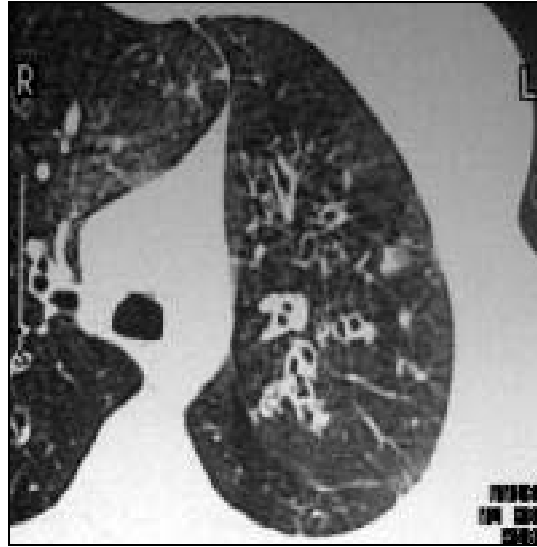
Computerized tomography (CT) scan shows cylindrical bronchiectasis with signet-ring appearance (*Tsang et al., 2005*).
